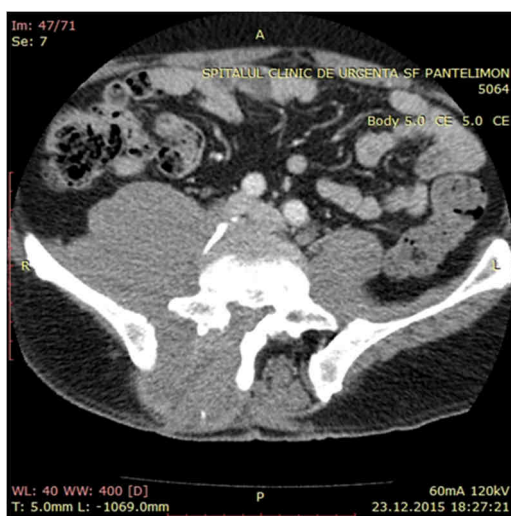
Postoperative (1 month) contrast lumbar CT at the level of the L5 vertebra showing the increase in size of both paravertebral masses
